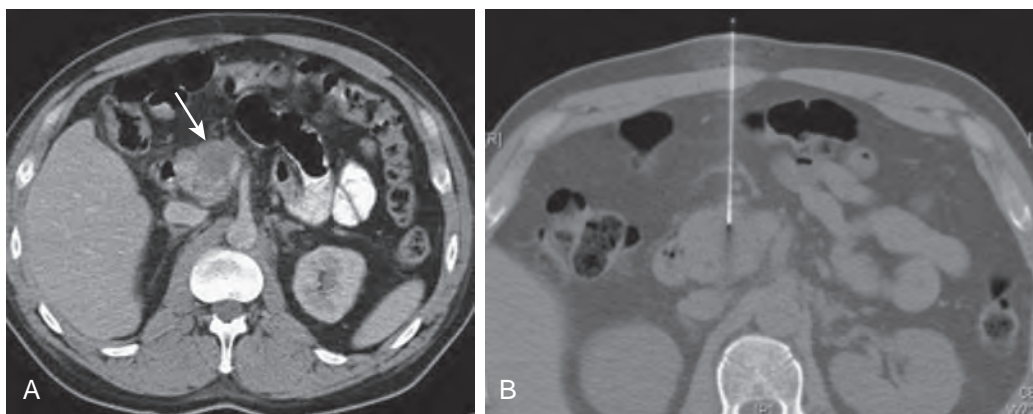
Percutaneous biopsy of unresectable pancreatic ductal adenocarcinoma. A. Axial contrast-enhanced CT image shows hypovascular mass (arrow) in the head of the pancreas with invasion of the portal venous confluence (indicating unresectability). B. Axial noncontrast CT image shows needle sampling (25 gauge) of pancreatic mass; cytology revealed ductal adenocarcinoma.
